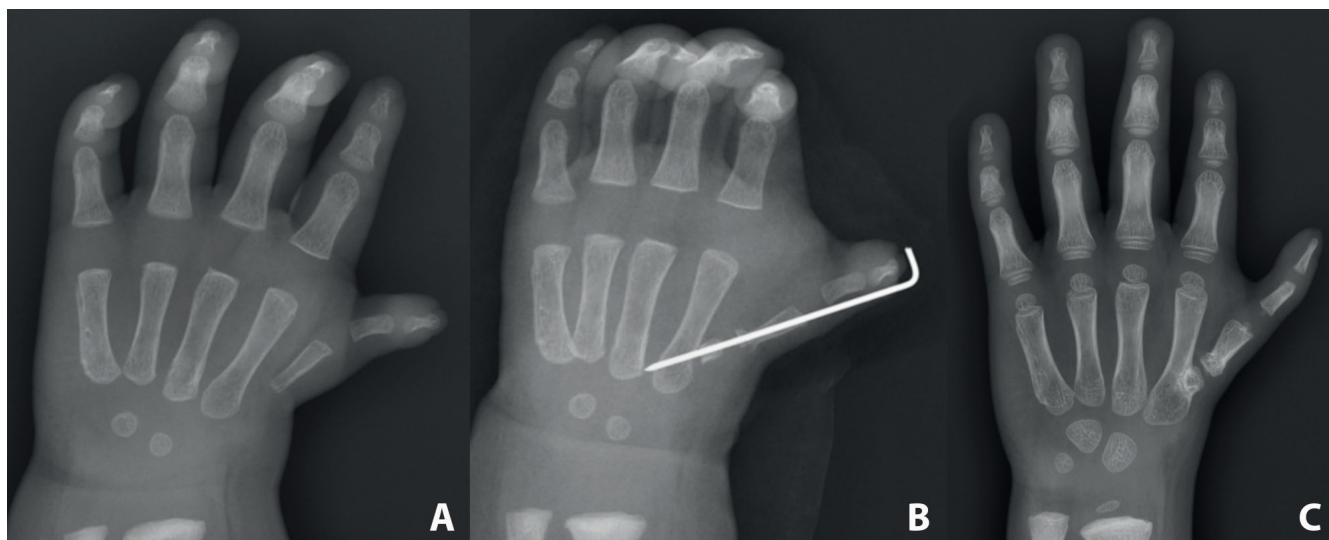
X-ray of one of the operated patients: hand in anterior-posterior (AP) position before (A), after the operation (B) and after 3 years (C)
